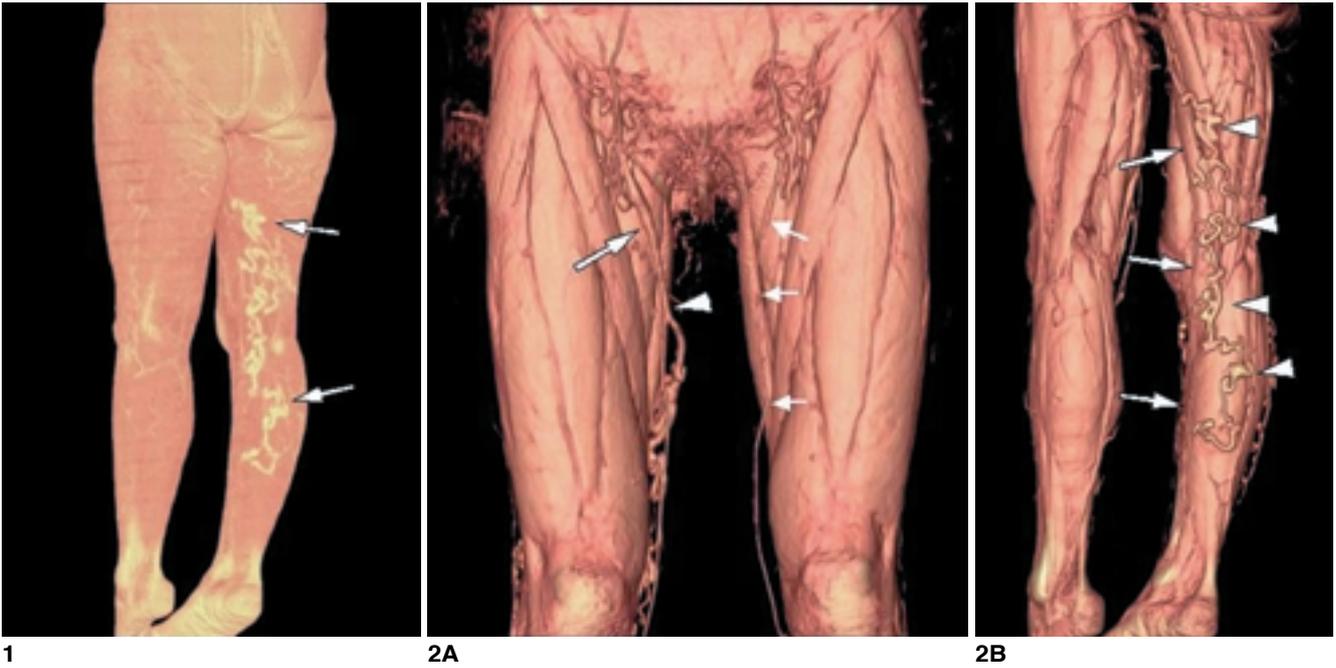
Volume rendering image of 3D-CTA shows the varicose vein (arrows) in the subcutaneous fat layer of the posterolateral aspect of the right thigh and calf.
